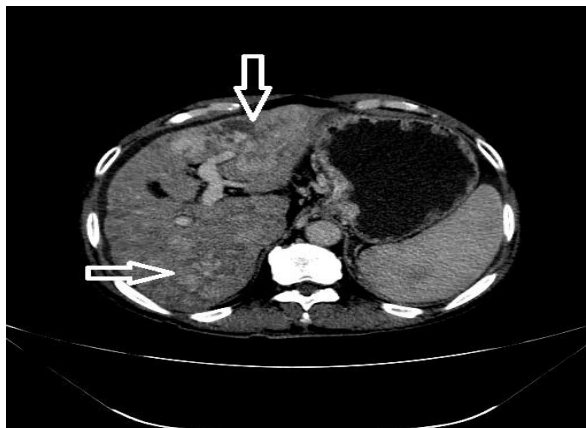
Venous Phase axial contrast enhanced computed tomography showing hyper enhancing ill-defined lesion (arrowhead) with ill-defined lesion in the right lobe (arrowhead)
